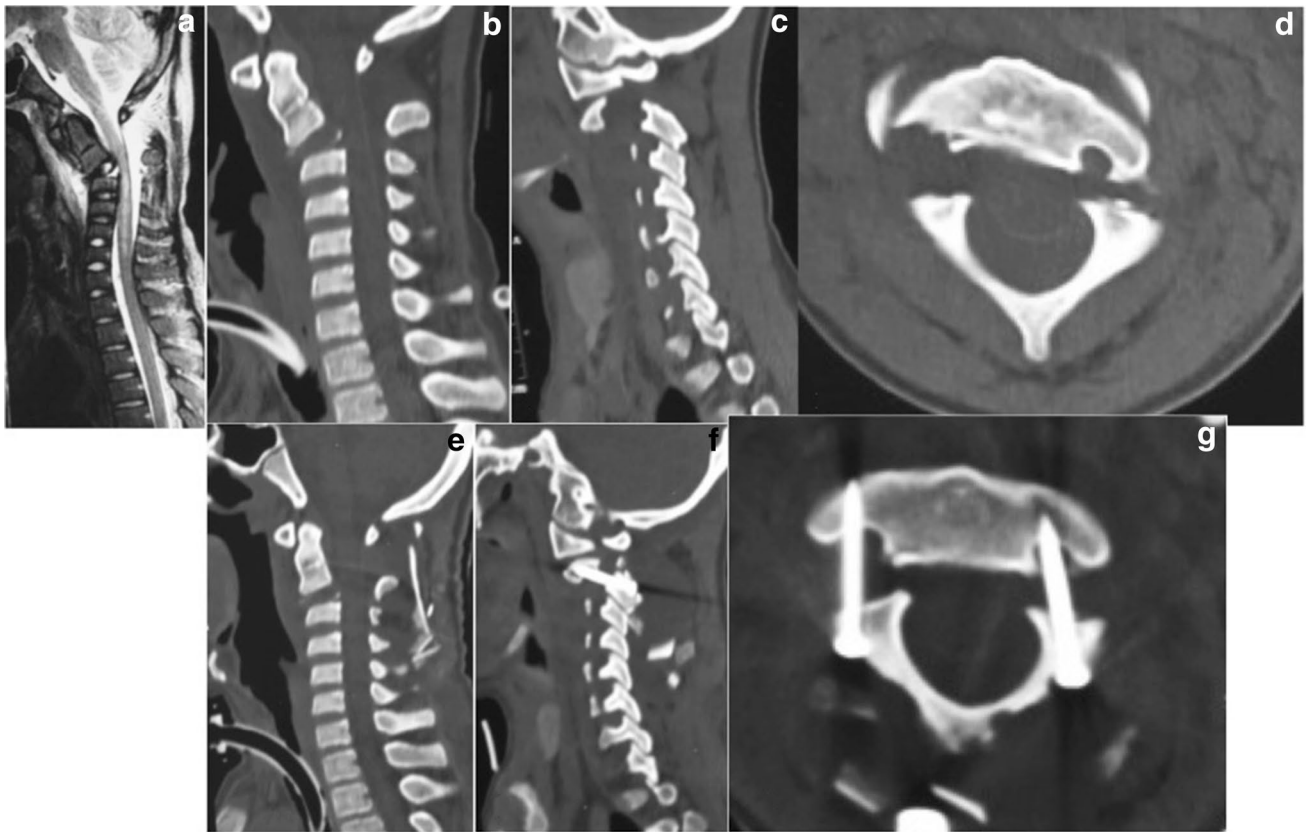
Images of a 14-year-old male patient. A: MRI showing the disruption of C2–3 disc space. B: CT scan showing the angulation of C2 vertebra and the disc space disruption. C: CT scan showing the fracture line and distraction of the fractured segments. The fracture line involves the articular surface of C2 facet (type 4). D: Axial view of C2 vertebra showing the fracture and distraction of the fractured
